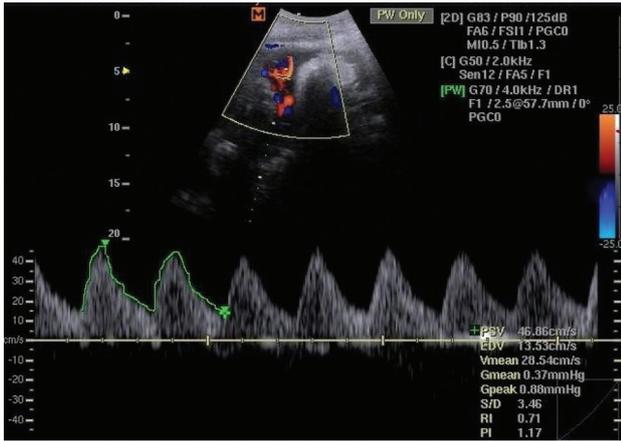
Umbilical artery Doppler for uncontrolled diabetic with adverse neonatal outcome (1-min APGAR score was less than 7).
